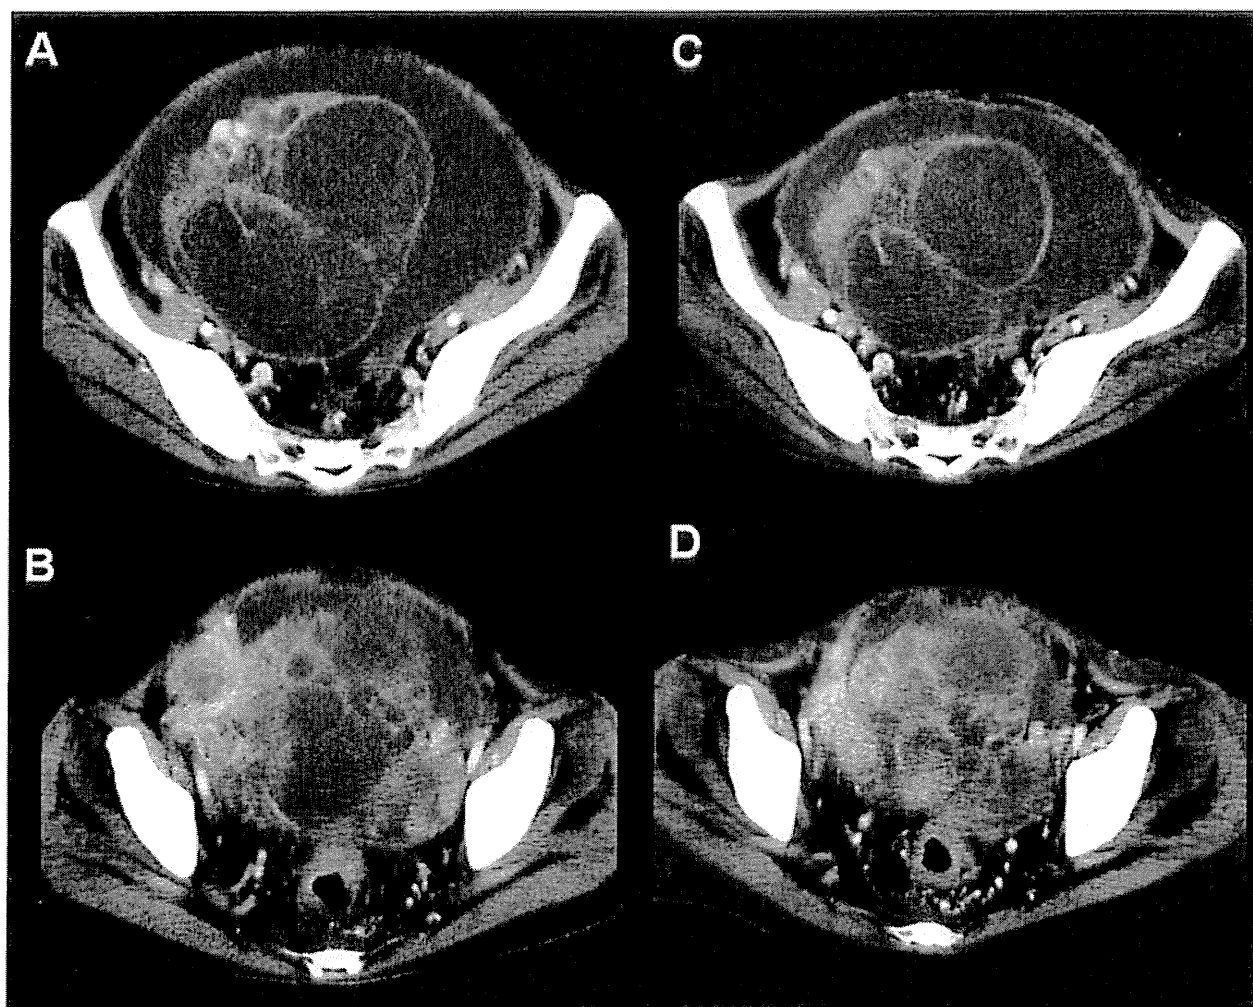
CT scan before and on trastuzumab monotherapy. (A–B) CT scans before treatment showed large ovarian metastasis with ascites. (C–D) CT scans after 6 administrations of trastuzumab showed that her ovarian tumors were slightly reduced.
